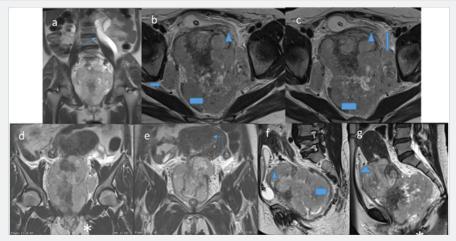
T2 weighted MRI Coronal (a,d,& e) Axial (b & c) and sagittal (f & g) reveals large utero-cervical heterogeneous mass showing intermediate T2 signal extending to lower third of vaginal shown by asterix in(image d & g.)Left sided hydro nephrosis and hydro ureter representing mass invading adjacent distal left ureter causing proximal obstructive changes (Thin arrow in image a). Urinary bladder is compressed by large mass with focal loss of normal T2 low signal of urinary bladder wall which appears thick and irregular could be edema or? Focal invasion, shown by triangle in image (b,c,f & g). Large bilateral iliac lymph nodes shown by thick arrow in image b &c. Rectum also compressed and displaced towards right side and loss of fat plane and normal T2 low signal of wall indicating invasion shown by rectangle in (image b,c & f). Incidentally noted sub septate uterus with remarkable widening of junctional zone representing diffuse adenomyosis shown by curved thin arrow in (image e).
